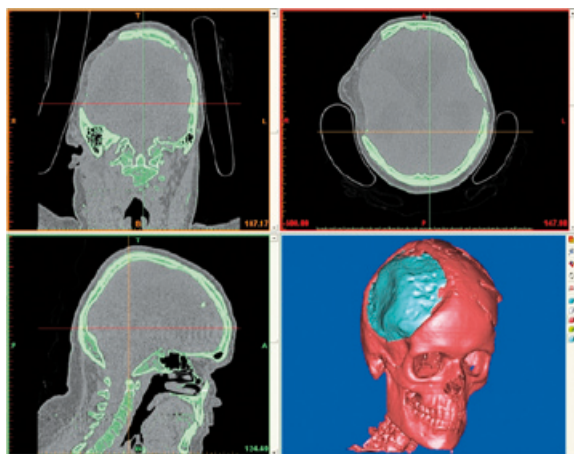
A 3D model is generated from the CT data.
